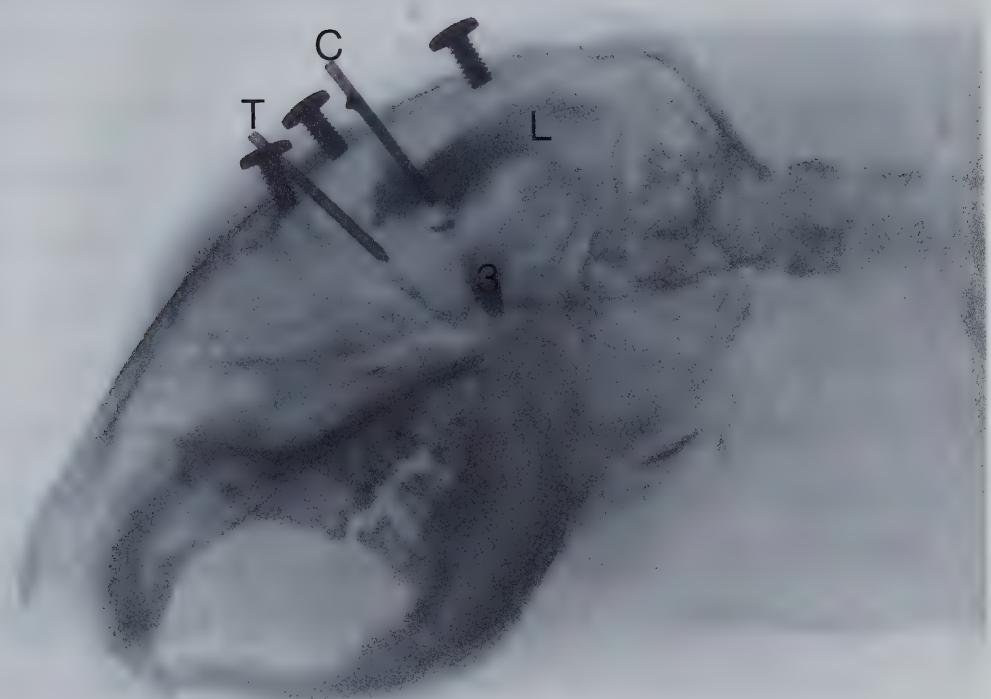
X-ray ventriculograph showing the diffusion of a radio-opaque dye (90% hypaque solution, 10  $\mu$ l) throughout the lateral and third ventricles 15 sec after injection through the cannula re-entry tube in an anaesthetised Richardson's ground squirrel. The thermocouple re-entry tube is located above the preoptic anterior hypothalamus. The 3 screws were used to anchor a protective acrylic cap (not shown) to the skull.
